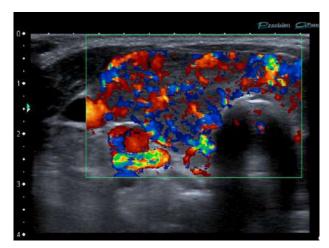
An example of thyroid dopplerography [6]
